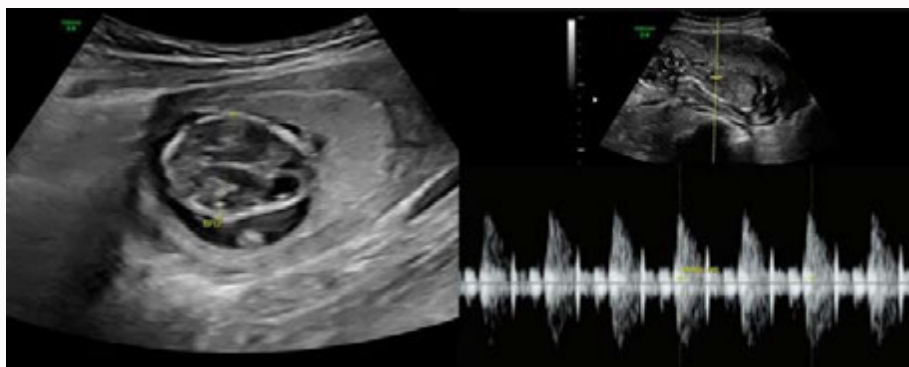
Ultrasonography done of admission revealed a live viable fetus of 13 weeks of gestation.
